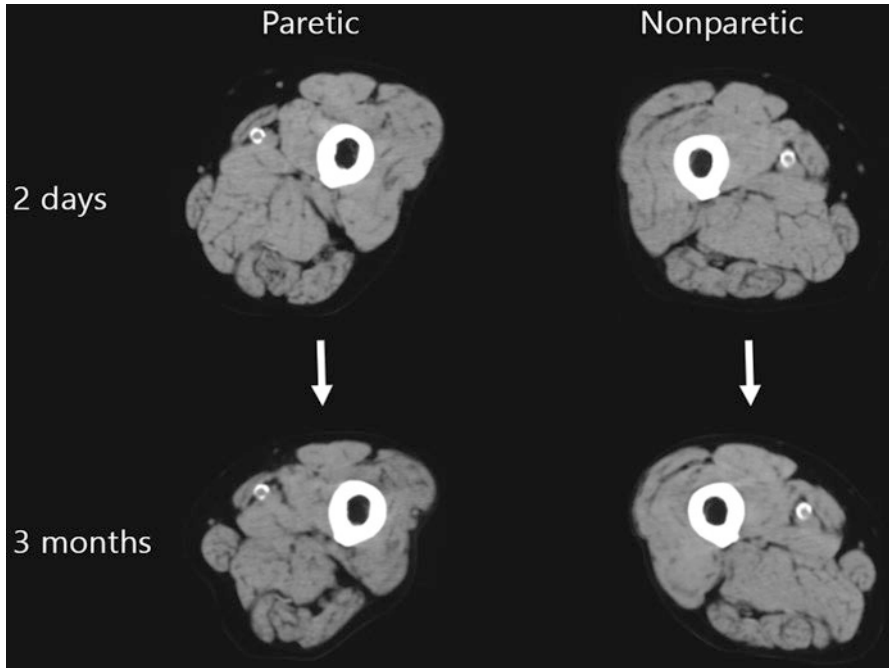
Femoral muscle volume changes observed from a computed tomography image taken from a 64-year-old elderly person. Images were made after 2 days and 3 months of immobilization due to the bedridden state from paretic (affected) and non-paretic legs [35]
